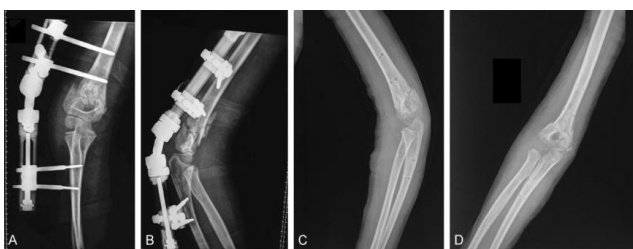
A) and B) Radiography at postoperative week 1 shows a good reduction of the fracture. C) and D) Radiography at postoperative week 6 shows the good union of the fractured ends without any deformities.
